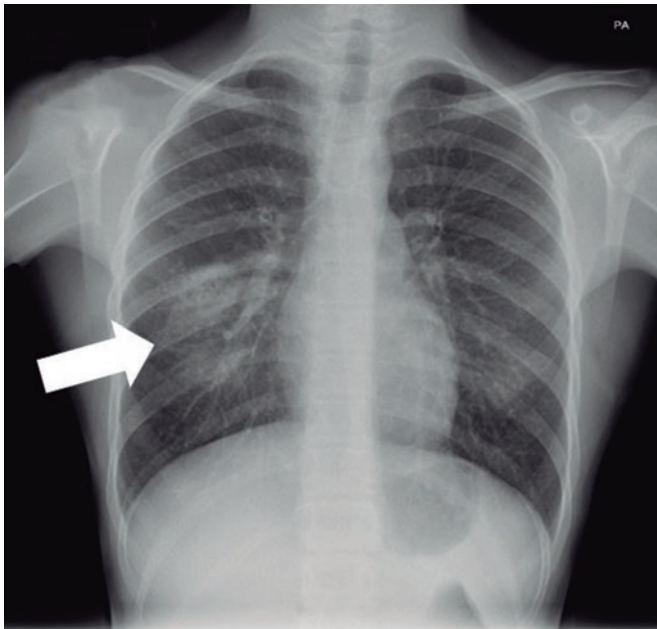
Pulmonary arteriovenous malformation seen on the x-ray (arrow).
